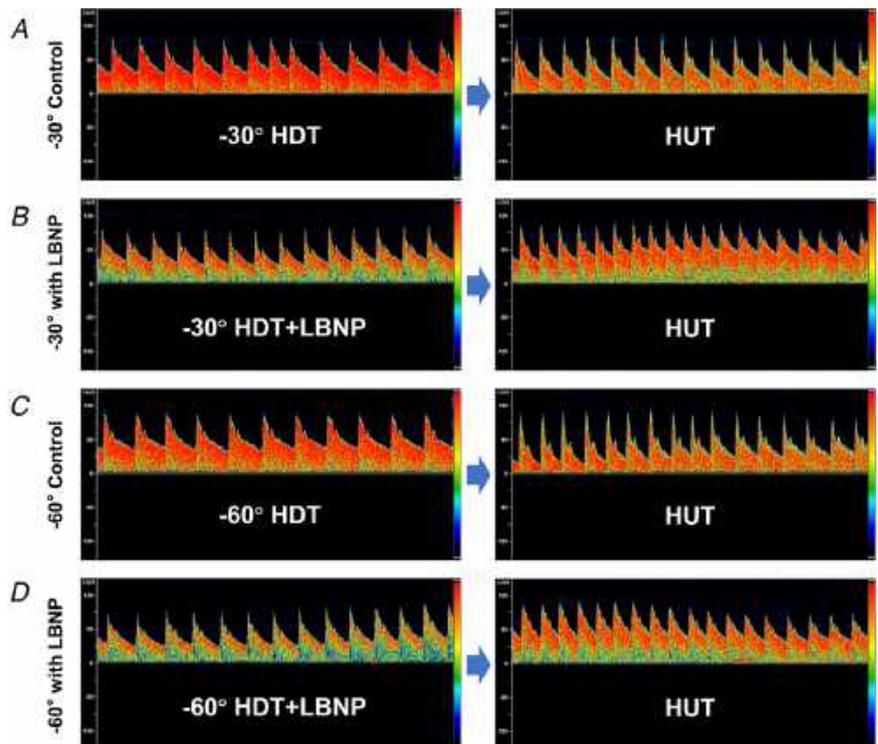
Representative transcranial Doppler records of cerebral blood flow during the rapid HDT to HUT transition
